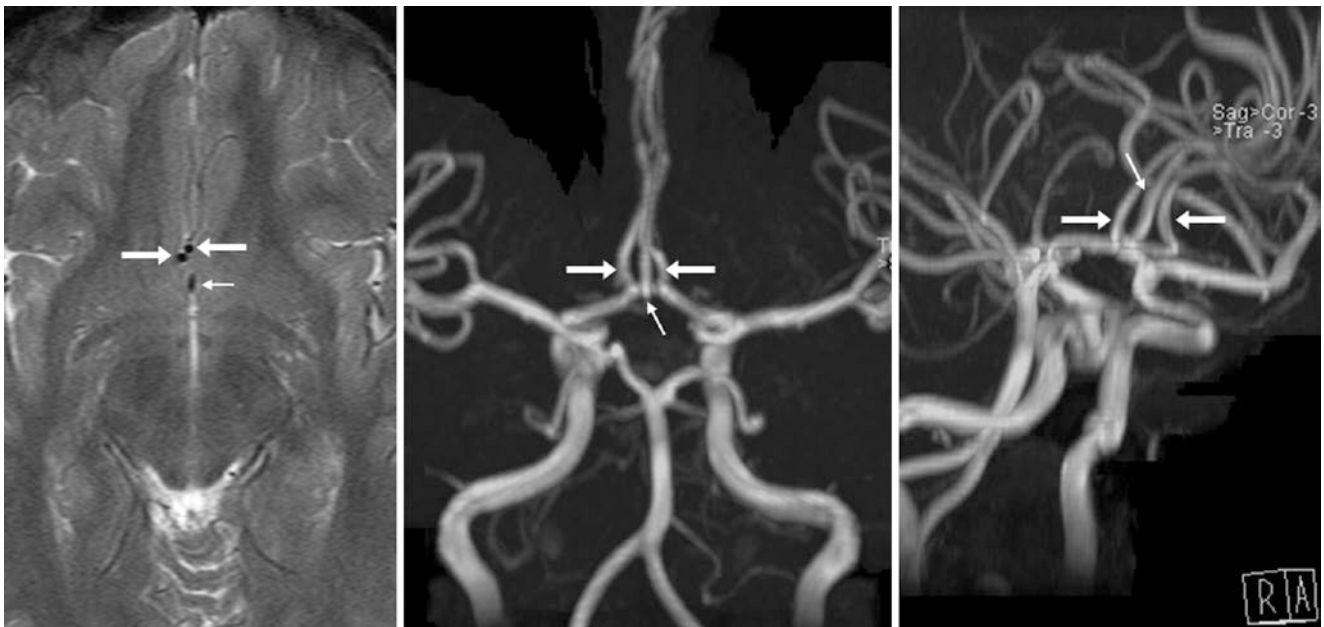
In this 15-year-old, an axial T2WI MRI (*left*) depicts three vessels (*arrows*) just above the AcoA, also seen on 3D TOF MRA AP (*middle*) and oblique (*right*) MIP views, indicating a persistent MACC (*thin arrows*)
